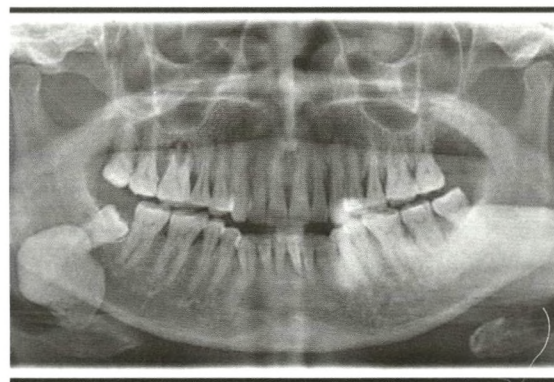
Panoramic radiograph image showing sialolith extending to mandibular right first permanent molar area.
